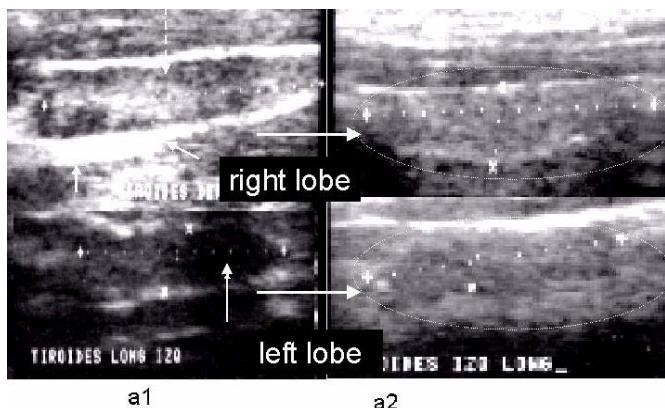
Thyroid ultrasound, pre (a1) and post (a2) treatment of toxoplasmosis. Note in 2a the large hypoechogenic image (arrow in dotted line) in the right lobe and the strong hyperechogenic halo (white, indicated by the arrow) as well as the nodular area (arrow in dotted line) surrounded by hypoechoic areas in the left lobe. In Fig. 2b, the change in echogenicity is observed (normal for the thyroid gland) as well as the reduction in the size of both lobes (transducer of 7.5 mHz).
